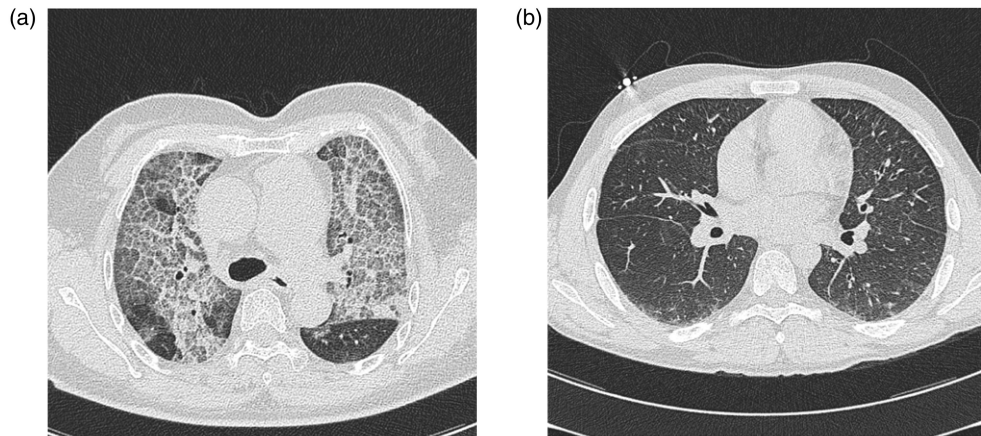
(a) This image shows the typical CT appearances of severe PAP with the 'crazy paving' effect, extensive airspace filling and some 'geographic' sparing of relatively normal looking lung. (b) Relatively normal CT appearance of healthy lung after successful treatment (different patient).
